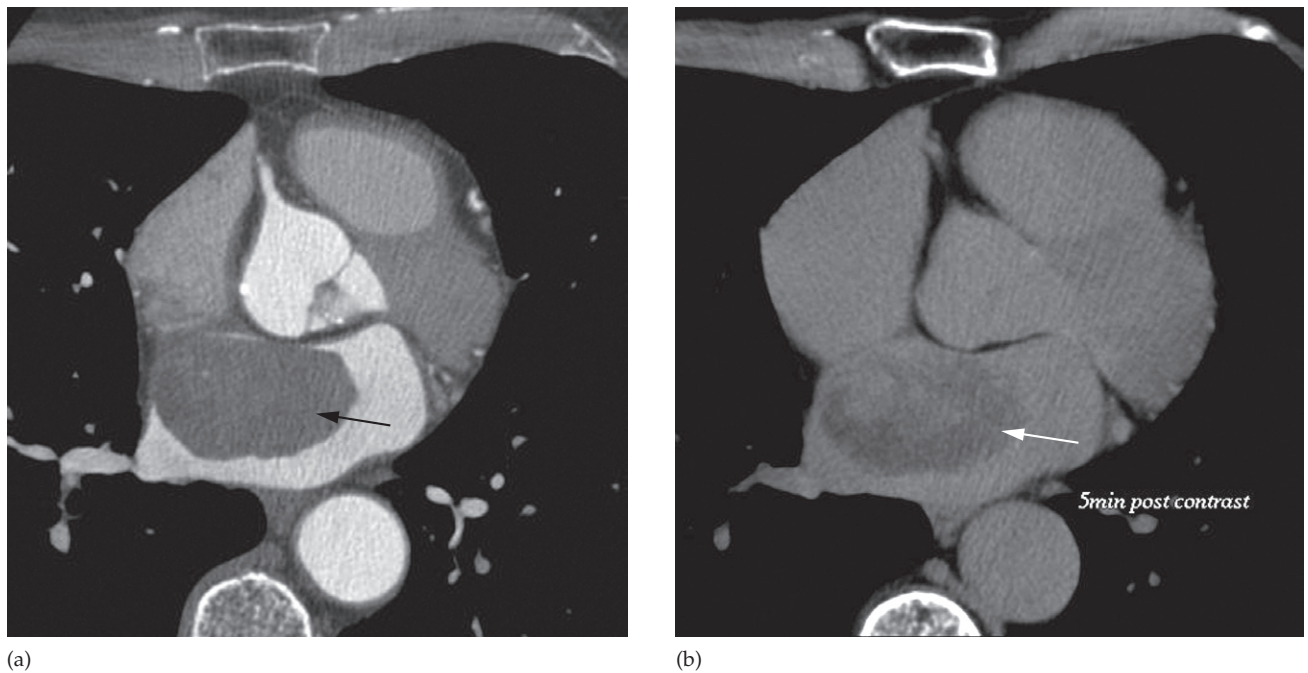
Left atrial myxoma. (a) Axial CT image in the arterial phase post contrast medium injection showing a smooth mass (approximately 4.5cm) in the left atrium (arrow). (b) Repeat scan 5 minutes post contrast injection revealing inhomogenous inner enhancement, which is typical in myxoma (arrow), although may also rarely be seen in thrombi.
